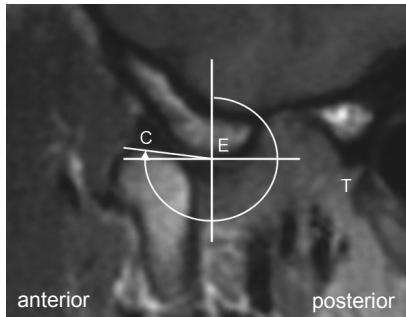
Sagittal MRI slice of a temporomandibular joint in maximum mouth opening position. A coordinate system is centred on point E with its x-axis parallel to the horizontal plane of the MRI. The angle between the line EC and the vertical axis was measured to quantify the condylar position relative to the articular eminence. E - summit lowest point of the articular eminence point; T - lowest point of the postglenoid tubercle; C - top condylar point.
